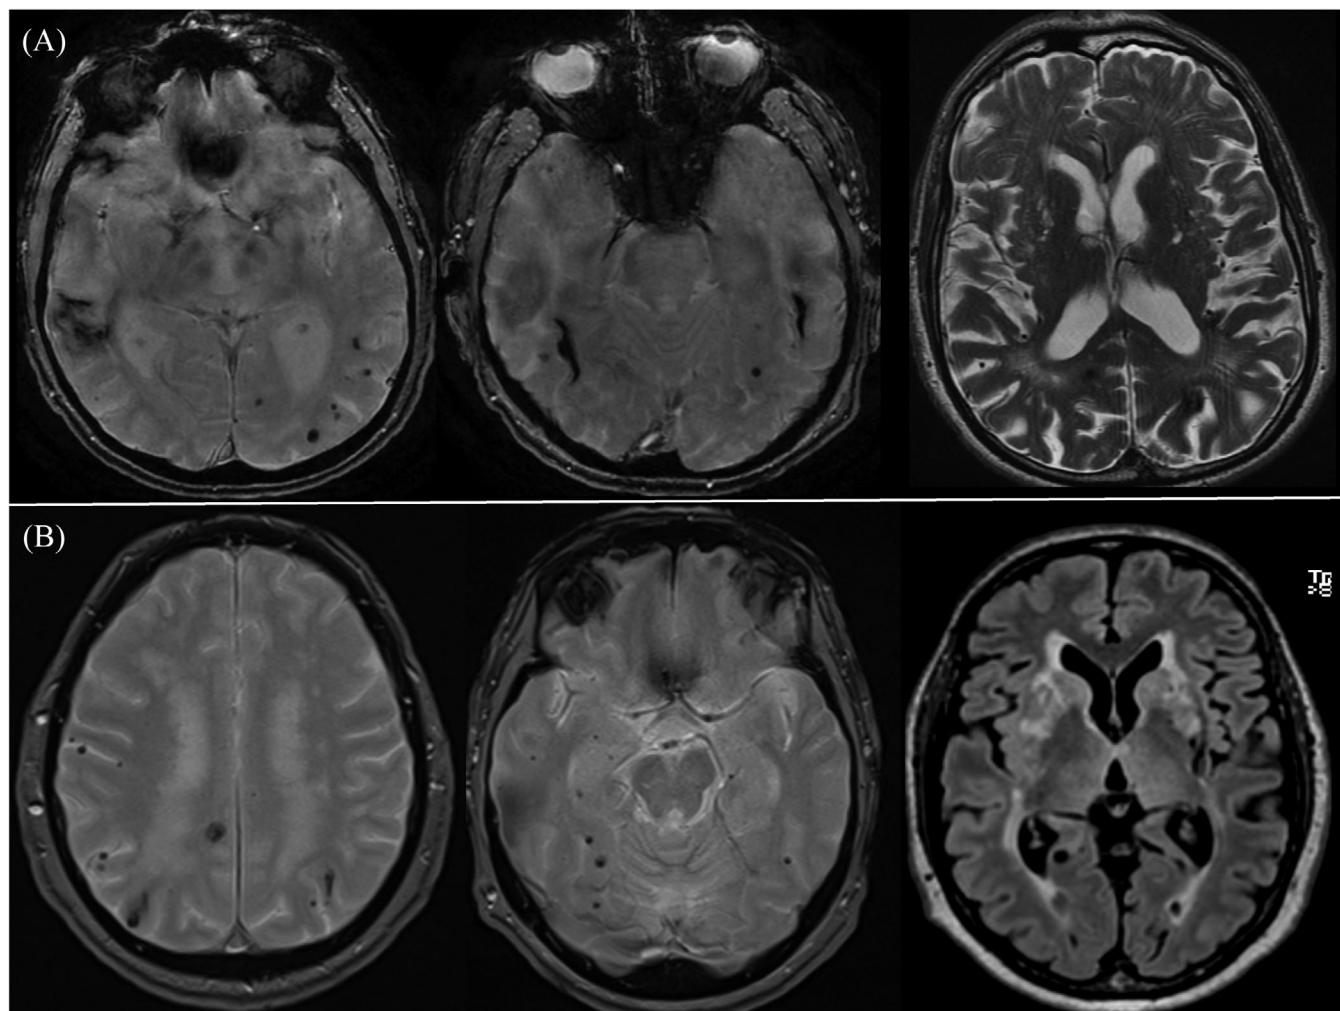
MRI imaging of the two carriers ROU-1149 (panel A) and EXT-1182 (panel B) of a pathogenic NOTCH3 variant presenting with a history initially compatible with CAA. Panel A: Left and middle axial T2-GRE weighted sequence showing several posterior lobar microbleeds and bilateral temporal ICH sequela; right: axial T2 weighted sequence showing mild periventricular white matter lesions of posterior topography and dilated perivascular spaces. Panel B: Left and middle axial T2-GRE weighted sequence showing several posterior lobar microbleeds; right: axial FLAIR weighted sequence showing mild periventricular white matter lesions and previous thalamic stroke. CAA, cerebral amyloid angiopathy; ICH, intra-cerebral hemorrhage; MRI, magnetic resonance imaging.
